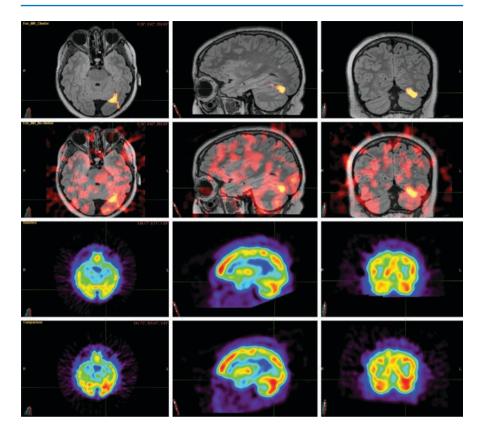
Subtraction ictal SPECT co-registered with MRI (SISCOM) demonstrating an epileptogenic zone in the right occipital cortex. The top panel is the final co-registered image; Panel 3 is the interictal SPECT; Panel 4 is the ictal SPECT
